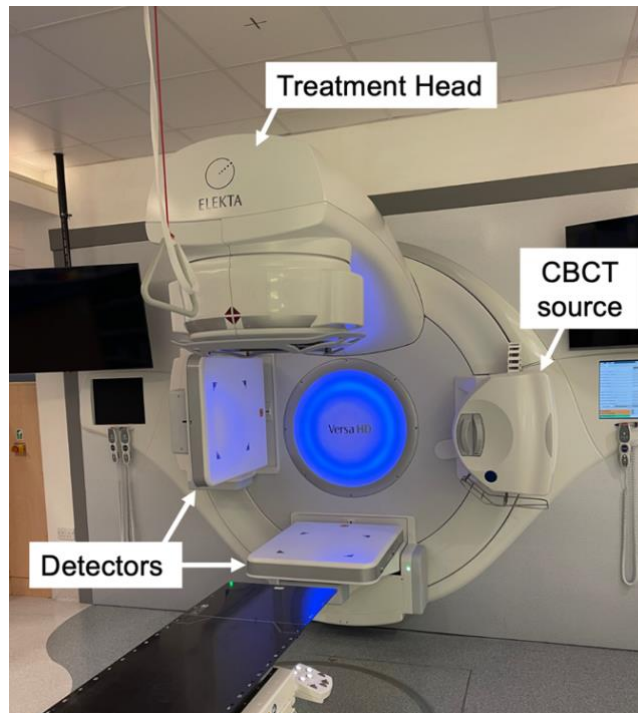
Linac equipped with CBCT positioned perpendicularly to the treatment head. The detector on the left is for CBCT detection (kV), while the detector at the bottom is used to detect megavoltage beam images directly from the treatment head.
